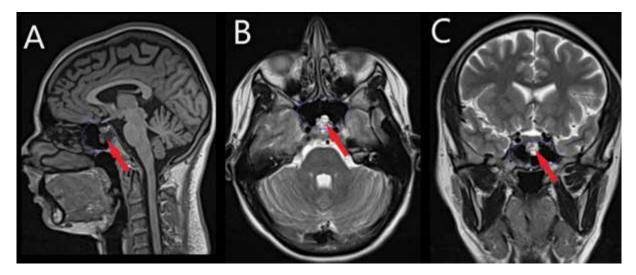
(A, B, and C). MRI of the brain and paranasal sinuses
